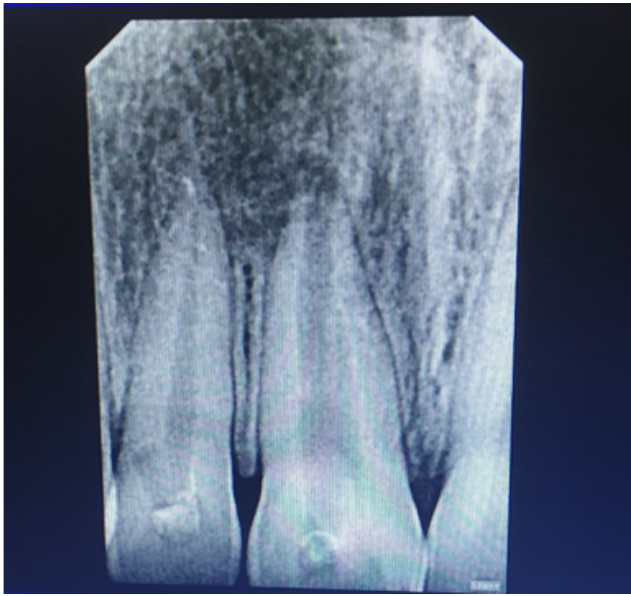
Radiograph after 4 months
